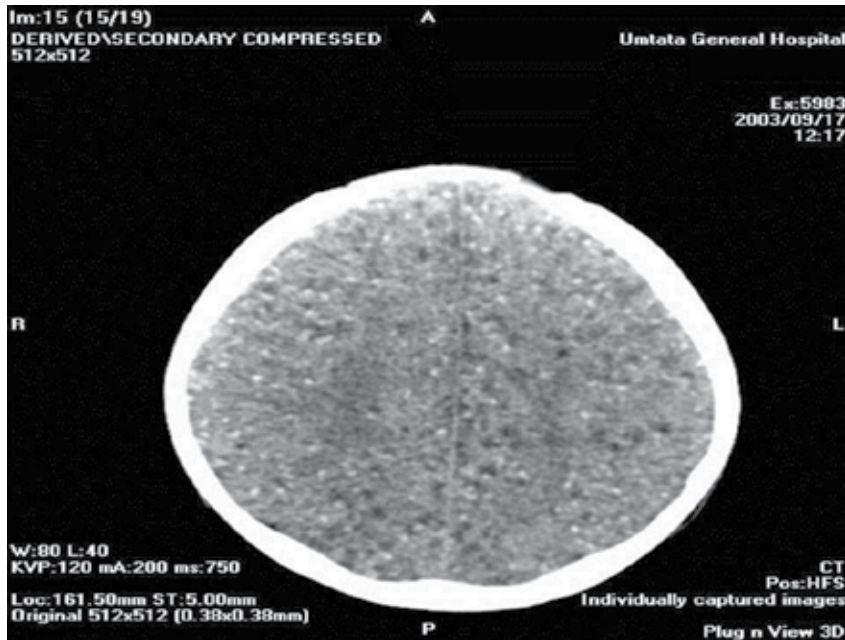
CT scans of the brain show severe NC.
